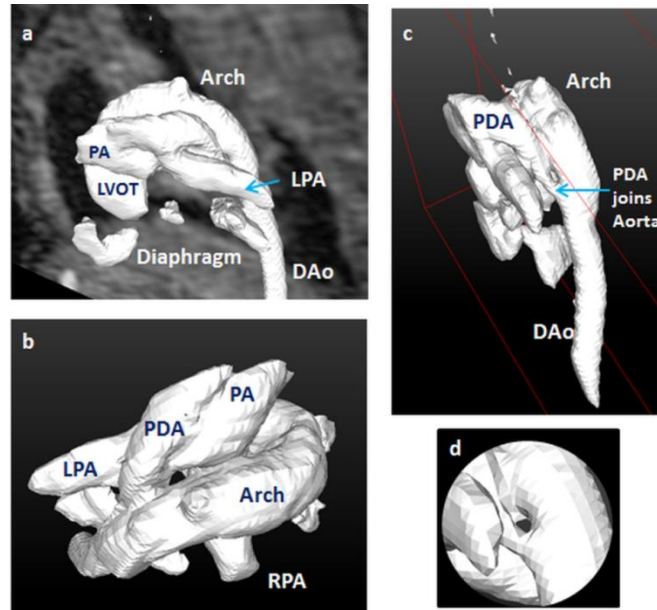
Vessel morphology: The PDA and great vessels can be observed from the angiogram in the P2 PDA infant (a, b and c). shunt volume was found to be 52.7% of LVO as determined by 2D PC MRI (chapter 4). Restriction of the duct can be seen at the proximal to the aorta (d).
